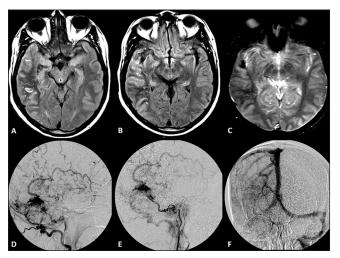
(a and b) Axial FLAIR MR images showing subcortical white matter T2 hypointensity in right parietotemporal lobe (c) Corresponding GRE image shows subtle blooming (d and e) Right ECA angiogram showing right transverse dAVF with venous reflux into superficial middle cerebral vein (f) Right proximal and distal transverse sinus occluded. Left transverse sinus patent
